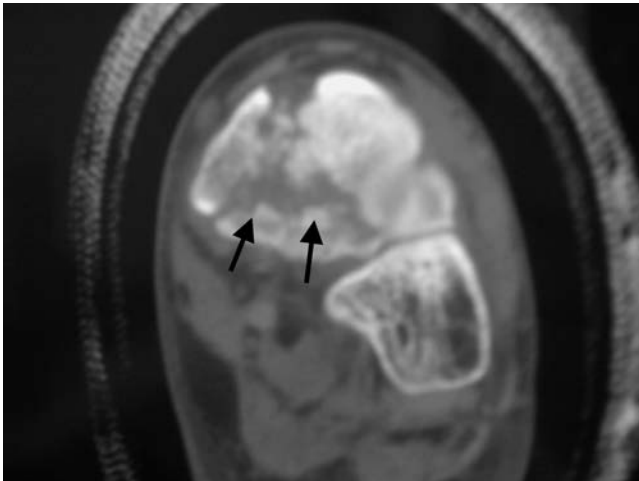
Computed tomography (coronal view) demonstrating more involved navicular body fracture with comminution.
